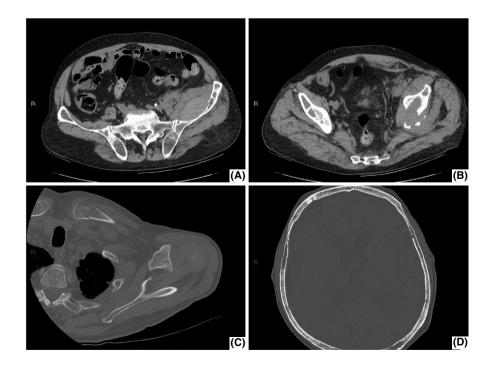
CT scan showing left ilium involvement and bone fracture (A and B), subsequently due to disease progression a left clavicule (C) and multiple cranial bone lesions (D)
